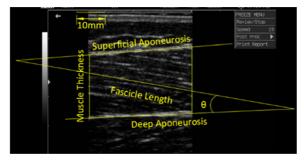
Ultrasound image of the vastus lateralis (VL). , pennation angle
